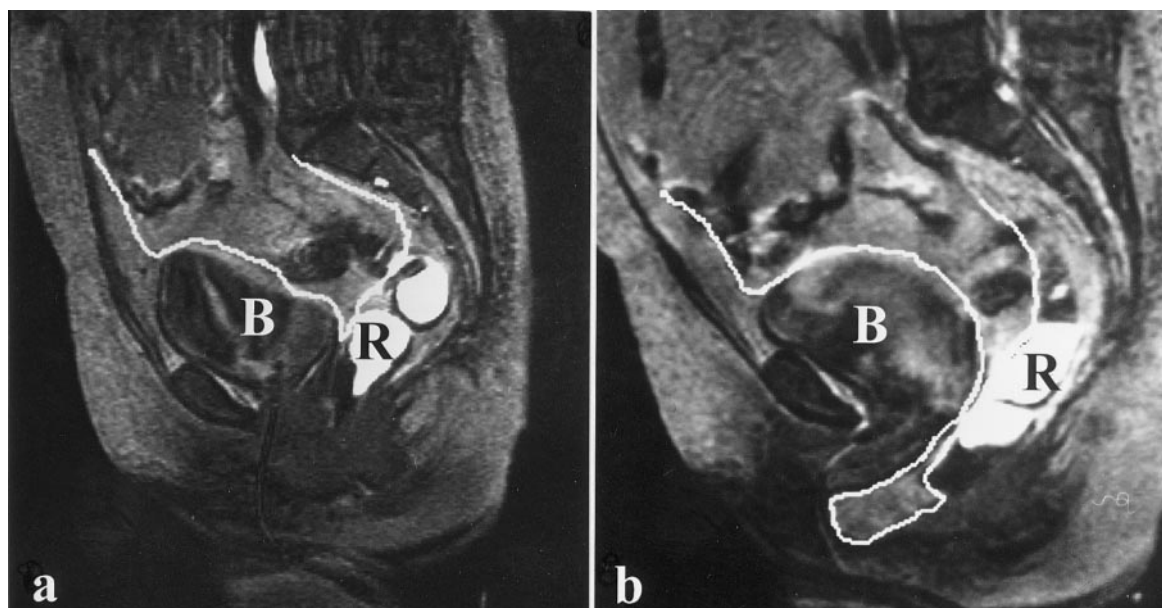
Sagittal MRI of the pelvis at rest (a) and during Valsalva maneuver (b) in a 63-year-old patient with vaginal prolapse following vaginal hysterectomy in 1975 and vaginal repair in 1980. Predominant enterocele (indicated by the line); a small rectocele (R) occurred during the Valsalva maneuver. B, bladder.
